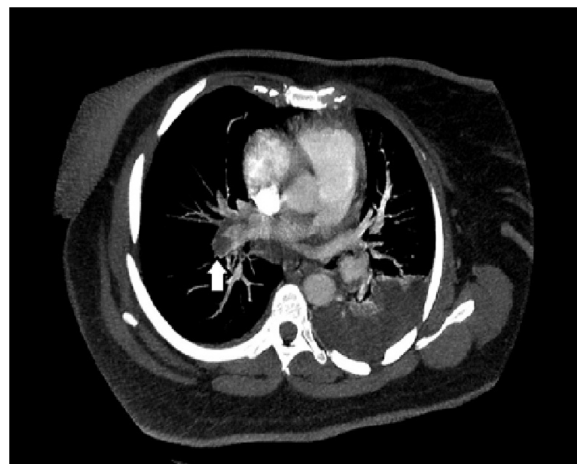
A computed tomography angiogram of the chest showing a large central embolus in the right main pulmonary artery and extending into the segmental branches.
